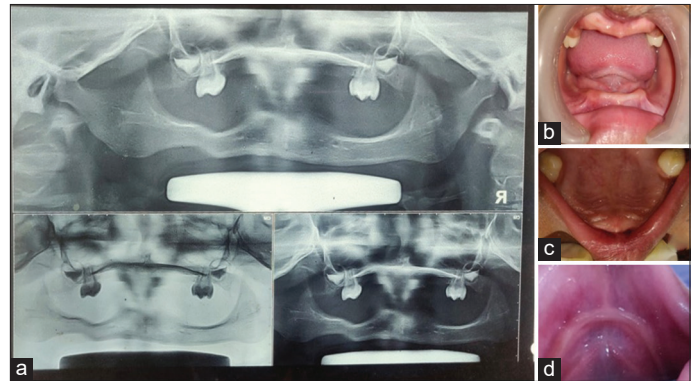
(a) Orthopantomogram for diagnostic evaluation; (b) Intraoral buccal view; (c) Maxillary, and (d) Mandibular occlusal view
